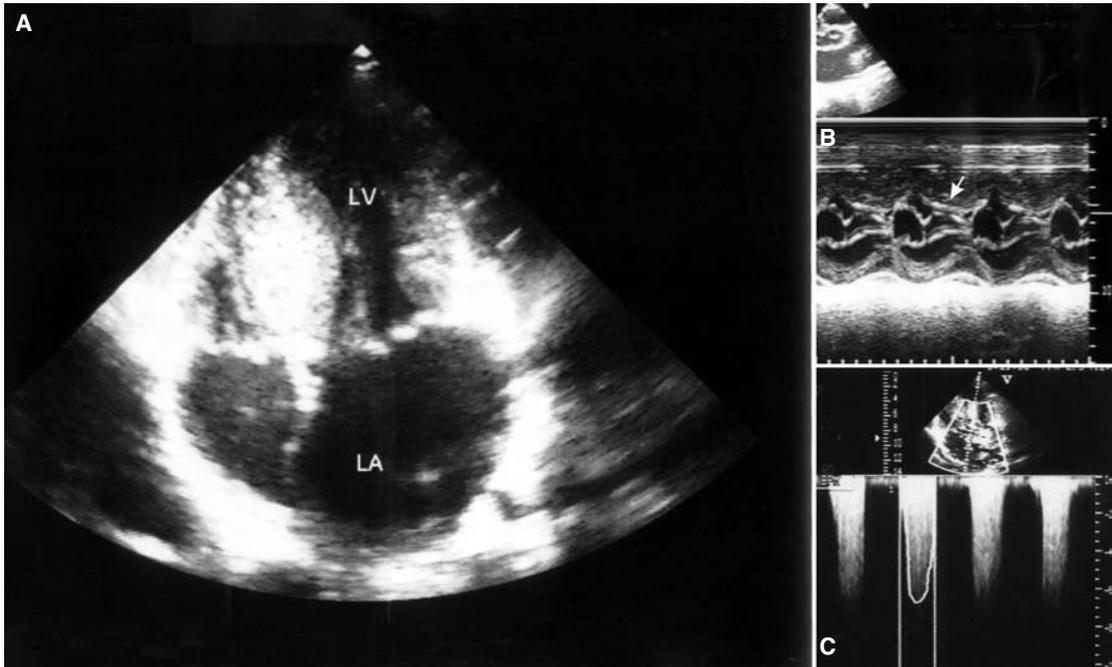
(A) Transthoracic echocardiography from the apical four-chamber view showing hypertrophic cardiomyopathy. (B) M-mode parasternal long-axis view at the mitral valve level showing septal hypertrophy and systolic anterior motion of the mitral leaflets (arrow) causing outflow tract obstruction. (C) A peak velocity of 6.7 m/sec and a mean of 110 mmHg gradient were detected at the outflow tract with Doppler echocardiography. LA: Left atrium; LV: Left ventricle.
